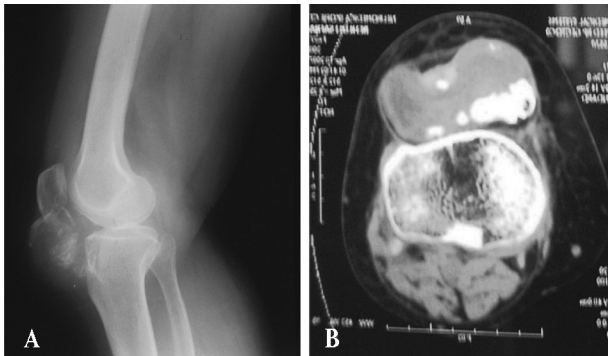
A. Lateral x-ray of the right knee, showing large infrapatellar chondroma B. Size and position of the chondroma
